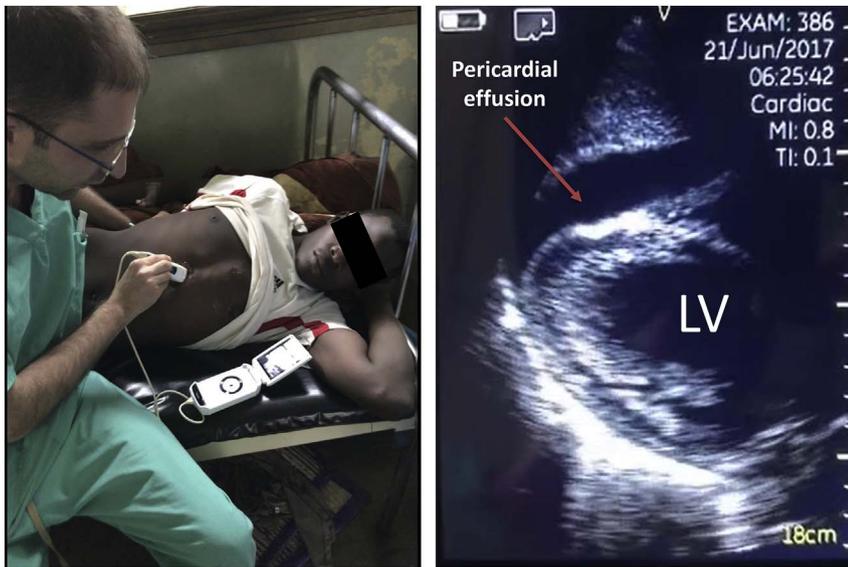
Focused cardiac ultrasound performed on 24 years old male with fever, cough and chest pain. The study shows large pericardial effusion without signs of tamponade. LV- Left Ventricle.
